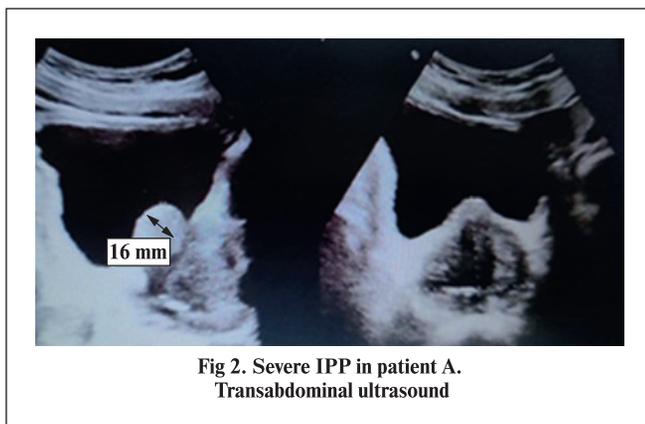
Severe IPP in patient A. Transabdominal ultrasound
